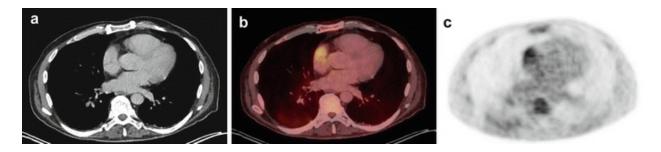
66 year old male patient undergoing PET/CT for tumor detection with known atrial fibrillation. Contrast enhanced CT (\mathbf{a}), fused PET/CT (\mathbf{b}) and PET images (\mathbf{c}) are displayed. A strong tracer uptake was noted in the left and the right atrium (displayed here) without morphological correlate indicating functional tracer uptake
